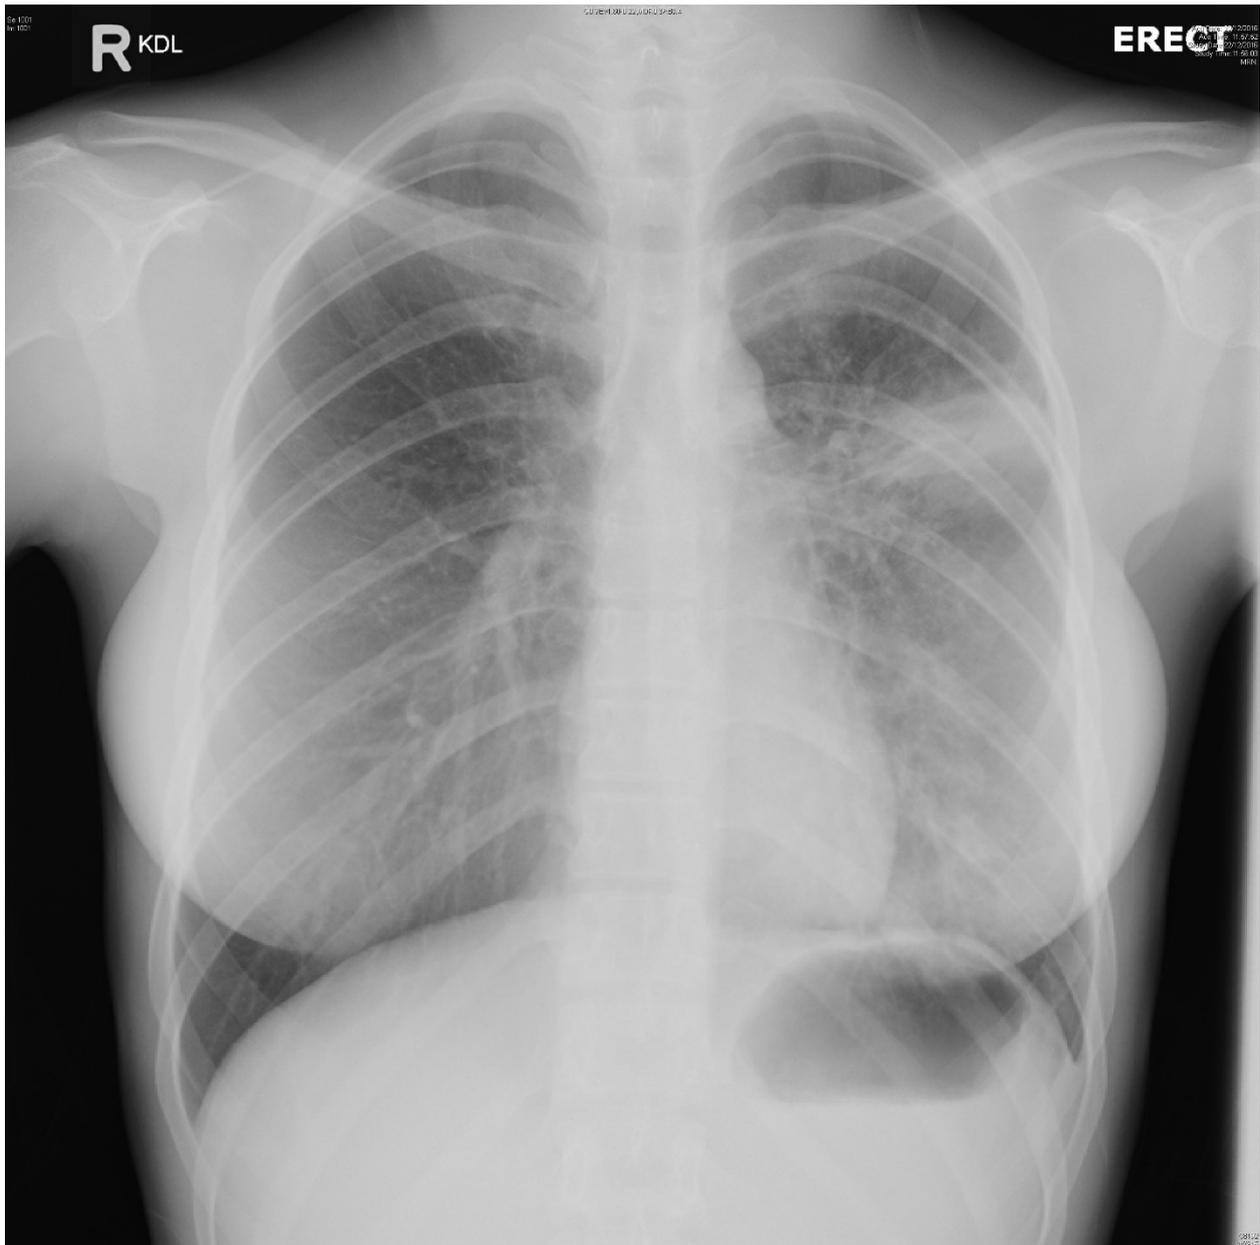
Patient's chest X-ray 1 week after discharge
